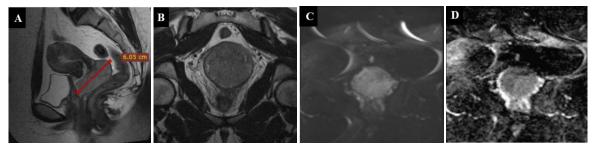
Pelvic MRI Examination of Case 1
